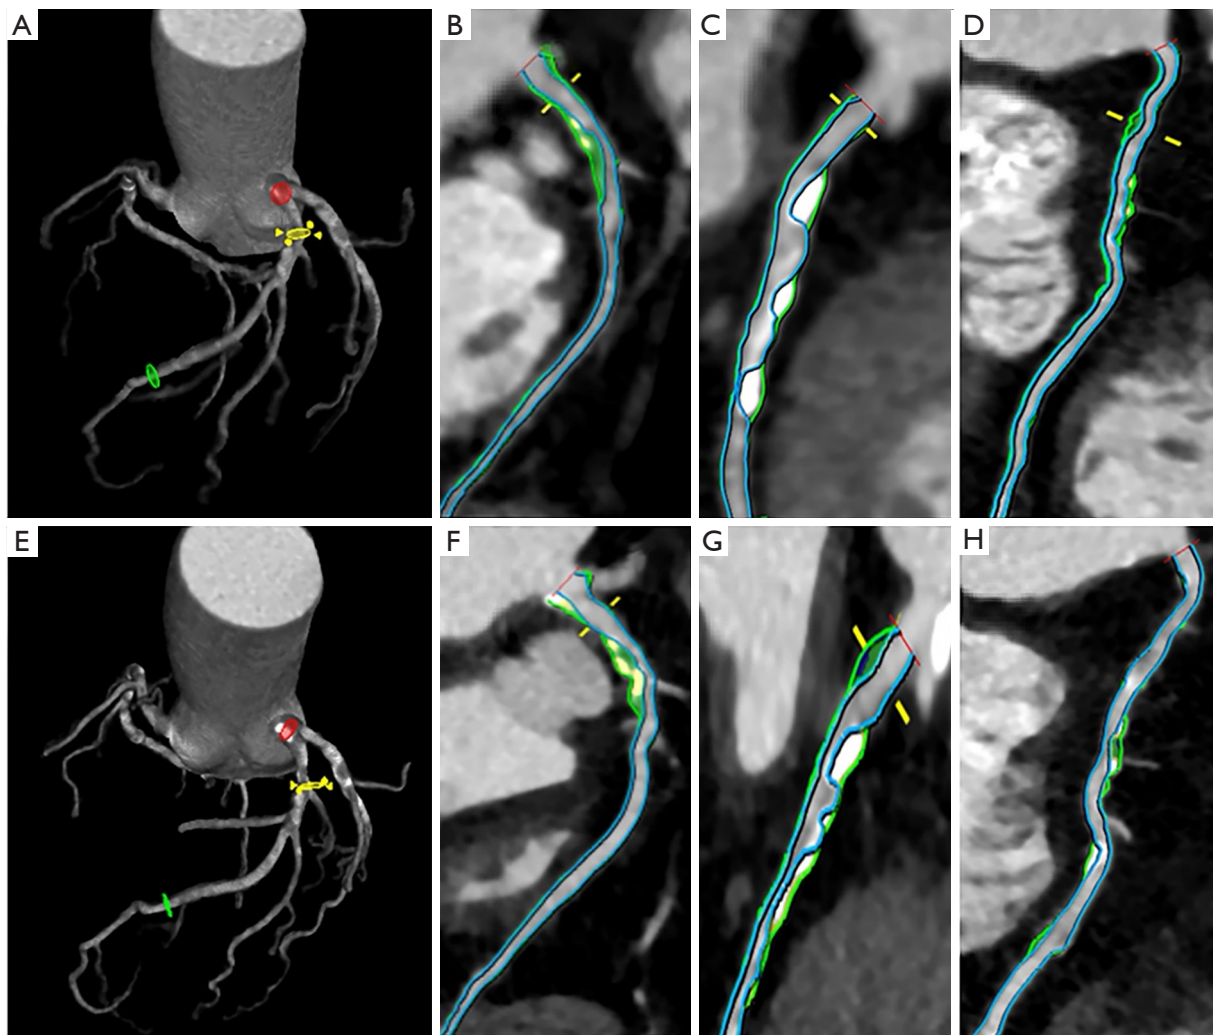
Baseline and follow-up CCTA reconstructed images of a 61-year-old woman without MACE. Baseline CCTA (A-D) showed mixed plaques in the left anterior descending, left circumflex, and right coronary arteries. The total, noncalcified, low attenuation, fibrous lipid, fibrous, and calcified PB were 107.4%, 78.6%, 1.4%, 18.5%, 58.7%, and 28.8%, respectively. The follow-up CCTA (E-H) showed the progression of total PB and enlargement of PCPB. The total, noncalcified, low attenuation, fibrous lipid, fibrous, and calcified PB were 118.8%, 74.0%, 5.0%, 26.7%, 42.3%, and 44.8%, respectively. The area outlined by the blue line is the coronary artery lumen, and the area between the green and blue lines is the coronary artery plaque. Yellow and white represent calcification and green represents noncalcification. CCTA, coronary computed tomographic angiography; MACE, major adverse cardiovascular event; PB, plaque burden; PCPB, percent calcified plaque burden.
